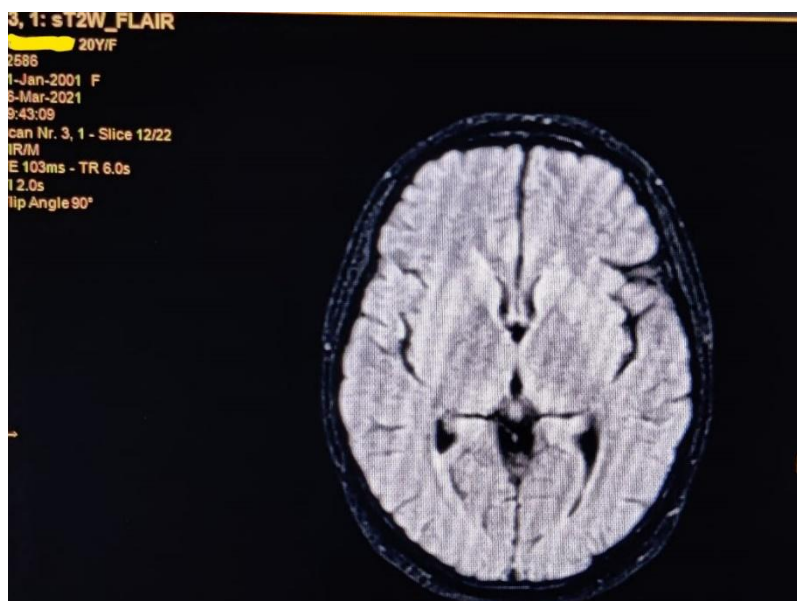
FLAIR-MRI BRAIN showing subtle hyperintensities in bilateral thalami.
